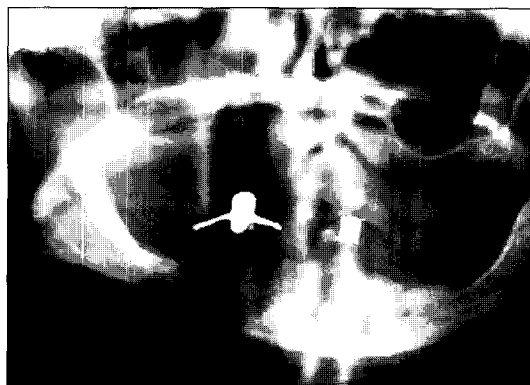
Pretreatment panoramic radiograph of edentulous arches.
